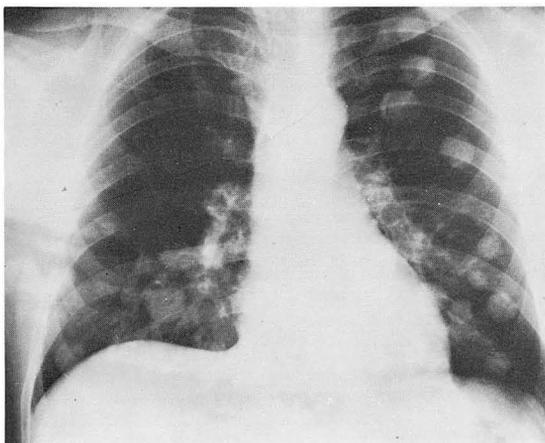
Chest X-ray : Multiple, wide-spread, variable-sized nodules in the entire both lung fields.
